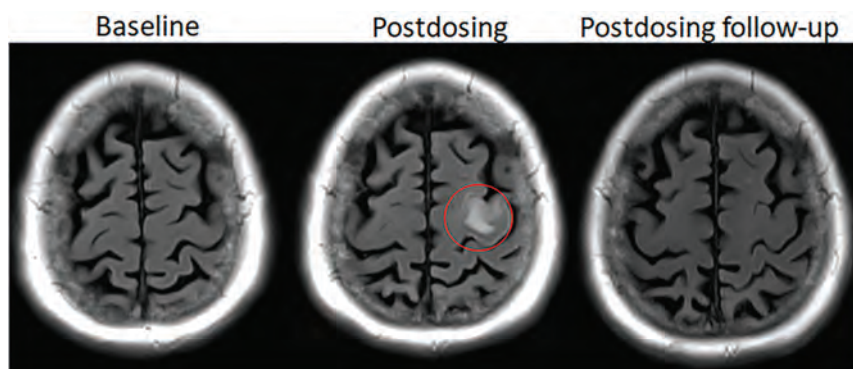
Dynamic and transient nature of ARIA-E. Axial T2 FLAIR images over 3 sequential time points for a patient undergoing anti-amyloid monoclonal antibody therapy. On the postdosing examination (middle, red circle), there is FLAIR hyperintensity involving the left superior frontal cortex and subcortical white matter measuring <5 cm in transverse dimension (mild ARIA-E) that is new from the baseline examination. On the 1-month postdosing follow-up examination, performed to reassess the ARIA-E, the left frontal FLAIR hyperintensity had resolved, as is typically seen and in keeping with the transient nature of ARIA-E. Images courtesy of Biogen.
